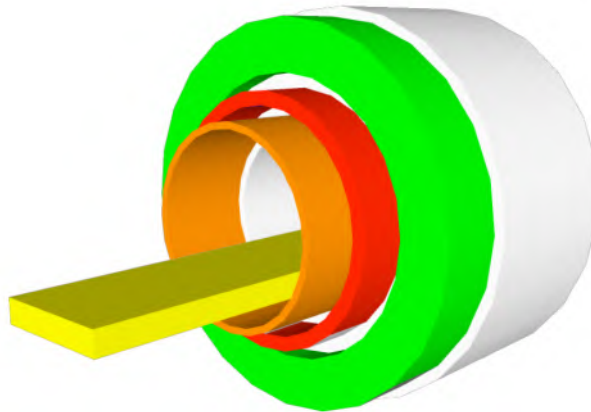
A cut through of an MRI scanner. Green: static magnet, red: gradient coils, orange: RF coils. [3]
